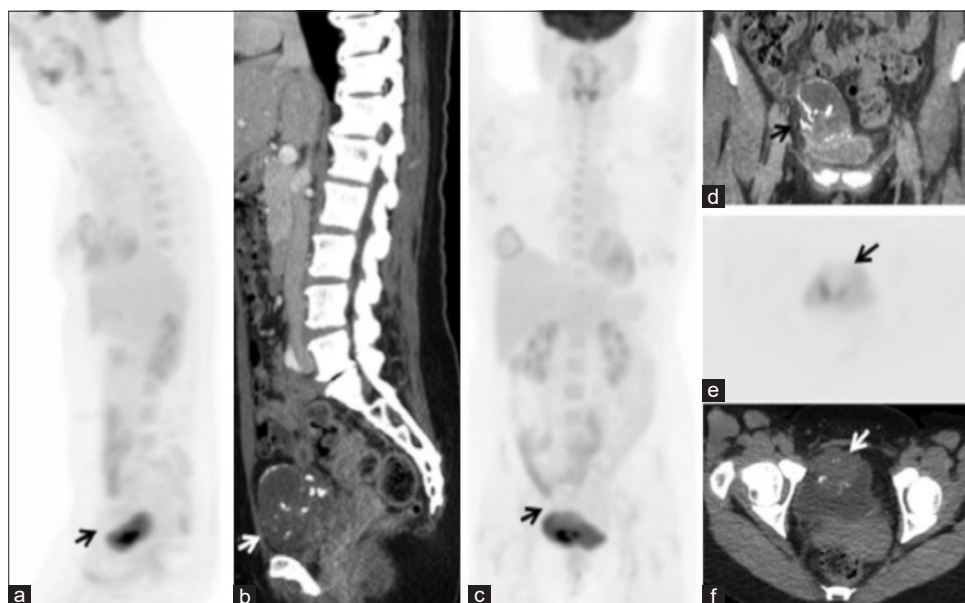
Sagittal positron emission tomography (a) and computed tomography (b) images, coronal positron emission tomography (c) and computed tomography (d) images, as well as axial positron emission tomography (e) and computed tomography (f) images, demonstrate a well-defined soft-tissue density (arrows) in the midline pelvis, superior to the bladder, exhibiting coarse central and peripheral calcification, and without abnormal fluorodeoxyglucose avidity
